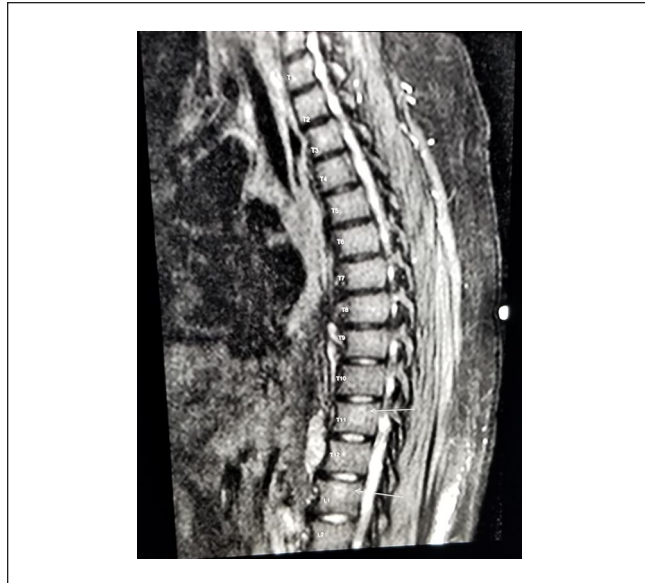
MRI thoracic spine showing vertebral body lesions at T11 and L1, suspicious for bone metastases.
